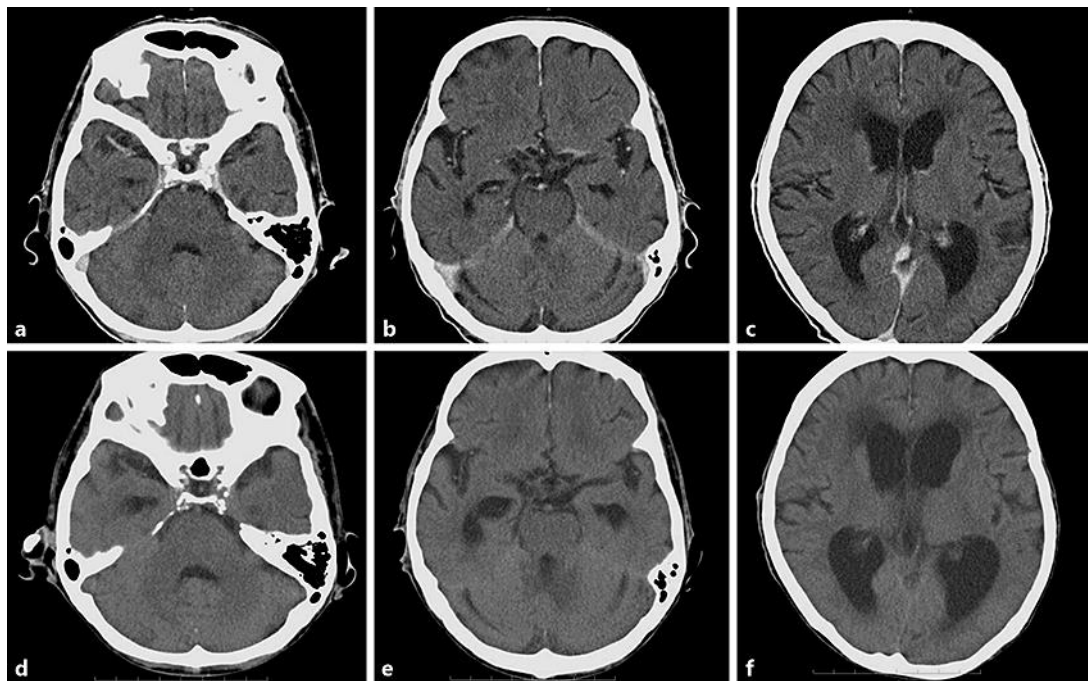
Findings on head CT scans. a–c Head CT scans at the time of admission are within normal range considering the patient's age. d–f Head CT scans on the 14th day of hospitalization. Clear ventricular enlargement and periventricular edematous changes are seen compared with those at the time of admission.
